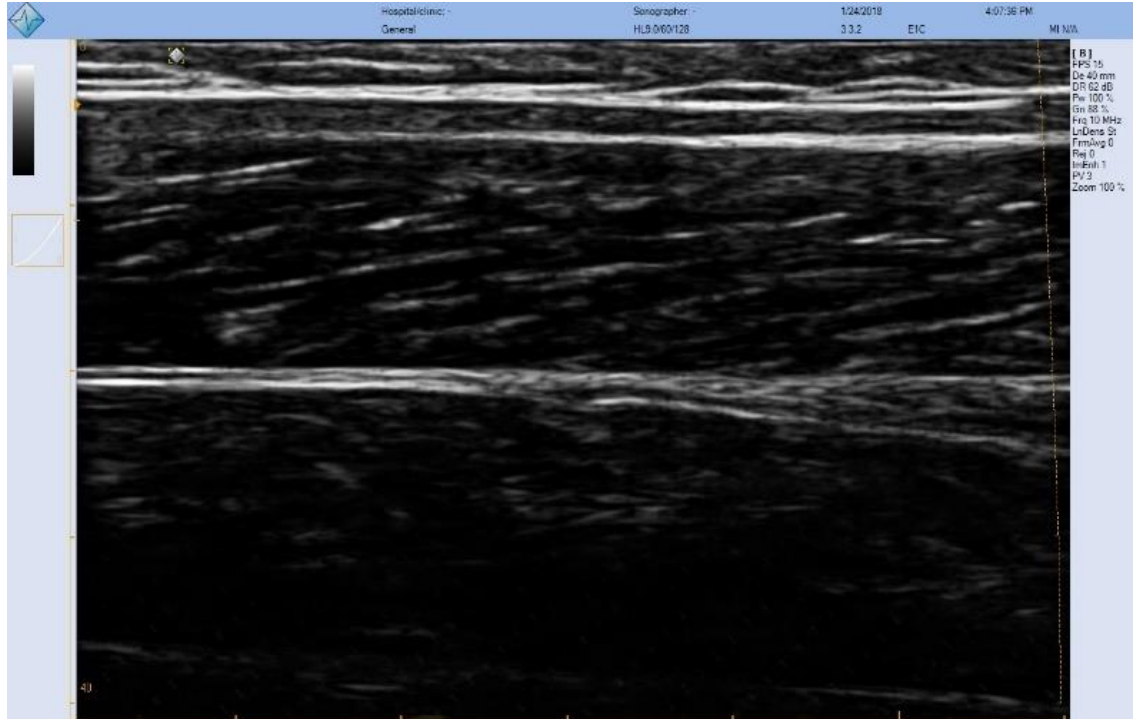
Ultrasound Image of MG
